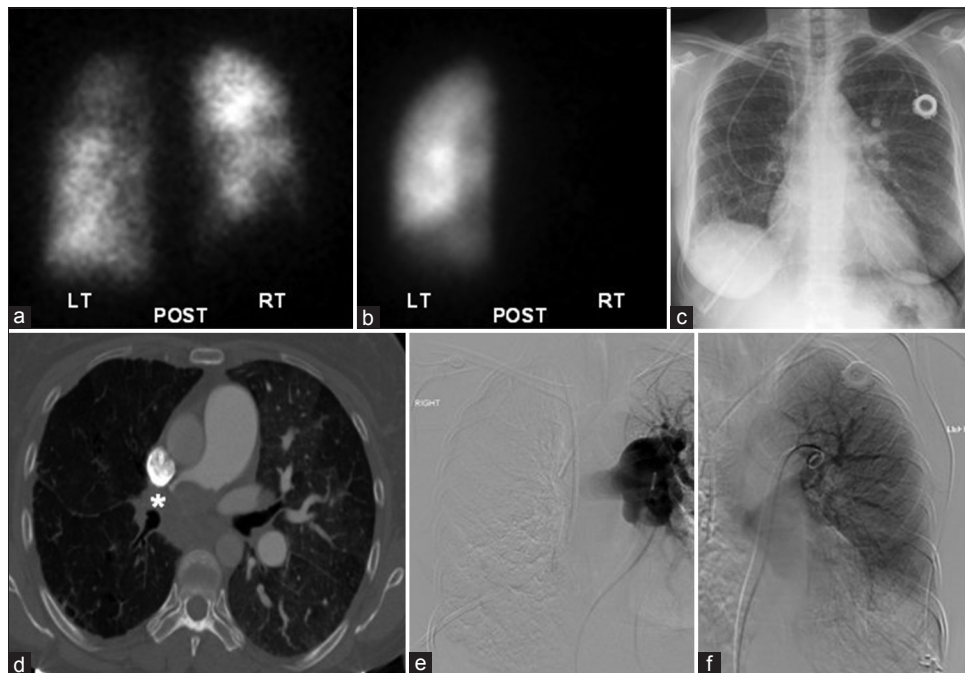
Large right pulmonary embolism. (a and b), Ventilation (a) and perfusion (b) images obtained with ventilation/perfusion scintigraphy: Mildly heterogeneous ventilation without perfusion to the right lung. (c) Chest radiograph: Mild interstitial thickening. (d) Computed tomography pulmonary angiogram: Right pulmonary artery occlusion secondary to pulmonary embolus (*) and decreased perfusion throughout right lung. (e and f), Conventional pulmonary angiograms: right pulmonary artery occlusion (e) and hypoperfusion of the lung (f). LT: Left; POST: Posterior; RT: Right
